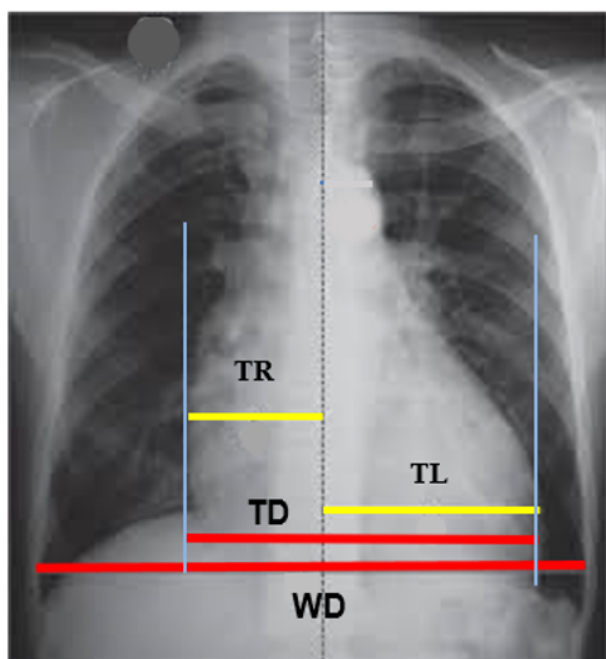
Chest X-ray PA View: Determine of the cardiac size. TL: Transversal Left, TR: Transversal Right, TD: Transversal diameter, WD: Widest diameter.
